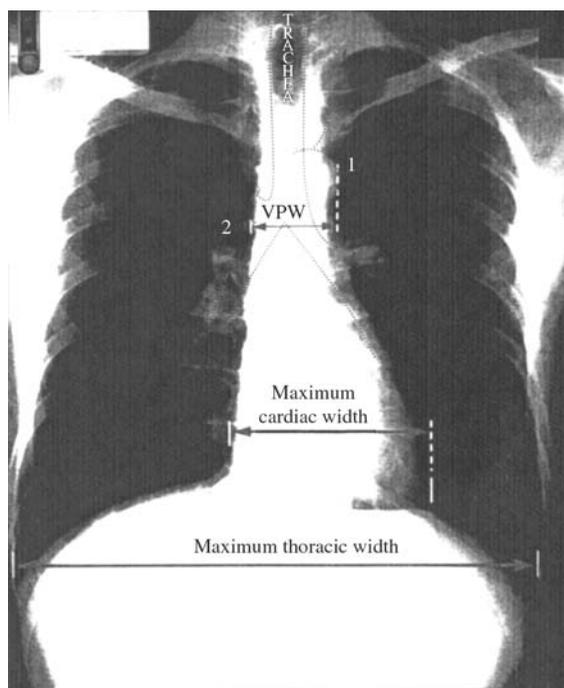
Representative image demonstrating landmarks by which to measure vascular pedicle width (VPW) on a chest radiograph. Point 1 represents the origin of the left subclavian artery as it exits the aortic arch. Point 2 indicates the superior vena cava crossing the right mainstem bronchus. VPW is determined as the distance between the perpendicular lines separating the two points. *Abbreviation:* VPW, vascular pedicle width. *Source:* From Ref. 80.
